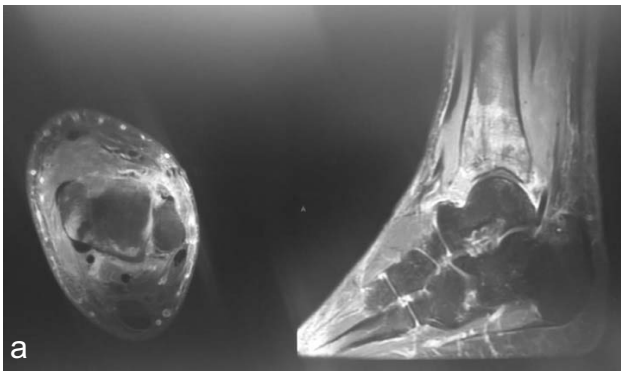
Image A showing MRI with high signal in distal tibial end along with soft tissue mass around it, Image B is increase tracer uptake on bone scan at the cooresponding site.
